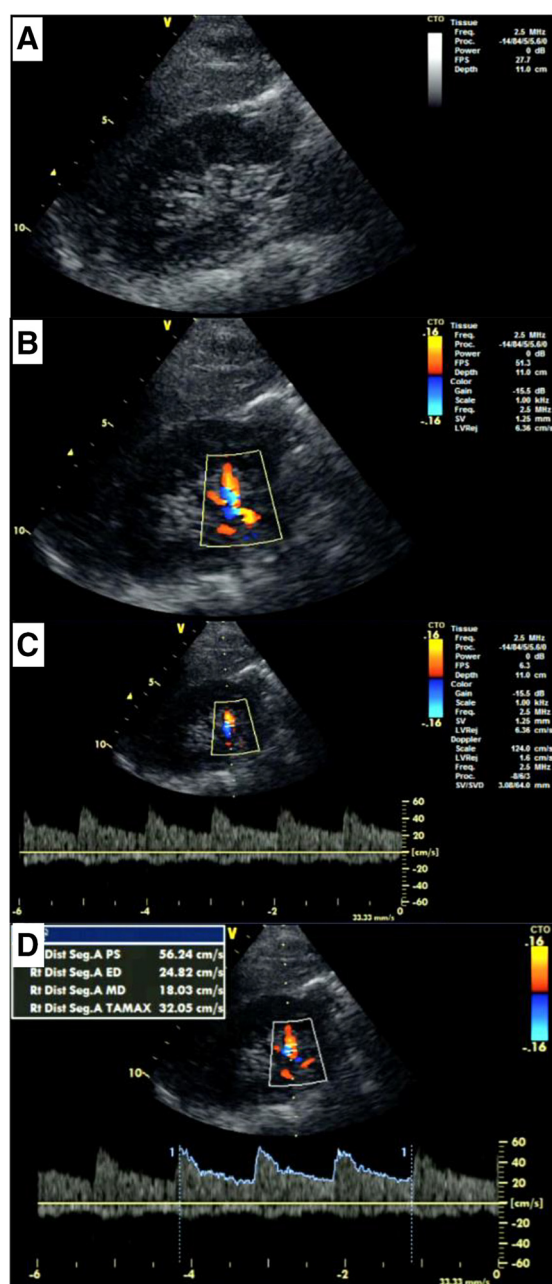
Doppler ultrasound imaging of the kidney. A: grayscale; B: color flow mode; C: pulsed wave velocity mode; D: segmental artery blood velocity envelope is traced over three cardiac cycles, and values for peak systolic velocity (PS), end-diastolic velocity (ED), and time-averaged maximum velocity (i.e., mean blood velocity, TAMAX) are presented.
